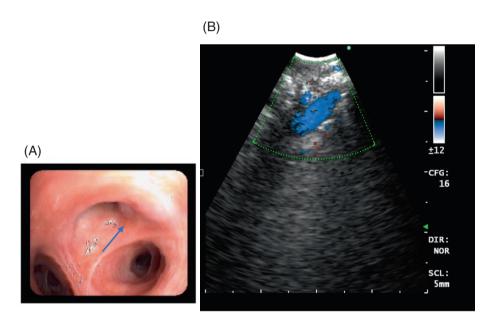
(A) White light bronchoscopy image shows a raised non pulsatile mucosal lesion in right upper lobe apical segment (blue arrow). (B) Convex probe EBUS image with Doppler shows the submucosal vessel in the same region. EBUS, endobronchial ultrasound.
